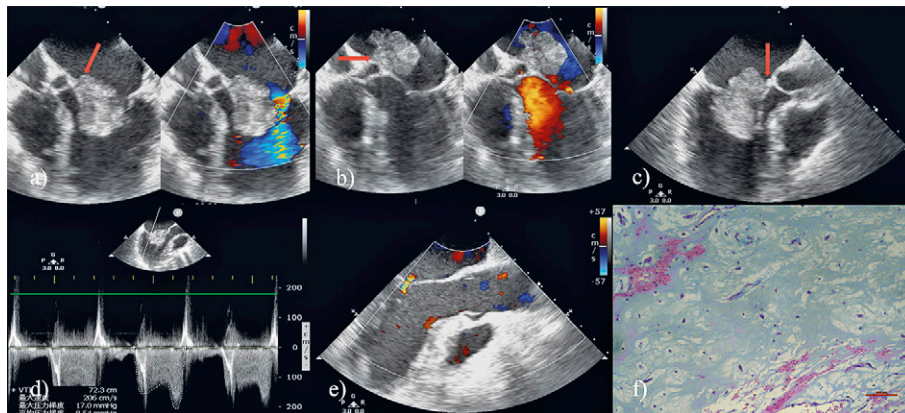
Fig 1. a) The mass caused an acceleration of mitral flow and attached to the mitral annulus; b) the mass protruded completely into the left atrium during systole but did not cause significant mitral regurgitation; c) the long-axis view of the left ventricle also shows that the diastolic mass protrudes into the left ventricle and the mass attached to the mitral annulus; d) Doppler examination showed a maximum flow velocity of 206 cm/s, and the mean pressure difference was 8.54 mmHg; e) the patient underwent laparoscopic mass resection with subtle mitral regurgitation after surgery; f) the postoperative pathological results suggested that the mass was myxoma.
